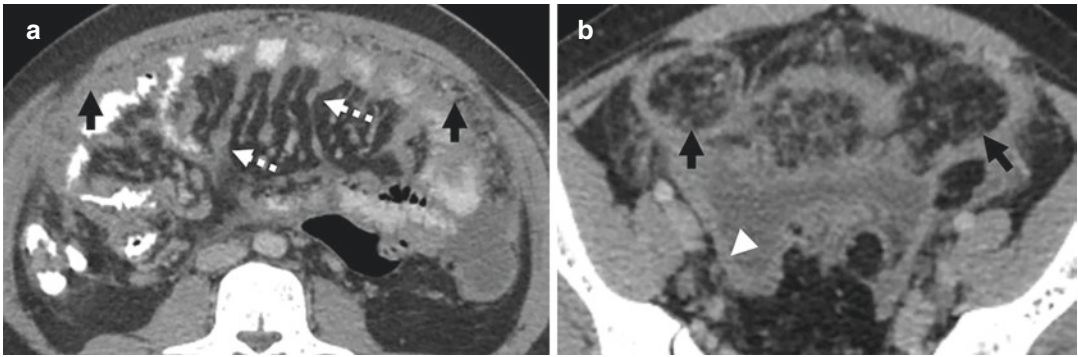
Peritoneal tuberculosis. (a and b) Axial contrast-enhanced CT images show diffuse peritoneal (white arrowhead), omental (black arrows), and mesenteric (dashed white arrows) thickening, nodularity and enhancement. (Courtesy of Dr. Jansi Sekar, Naruvi Hospital, Vellore, India)
